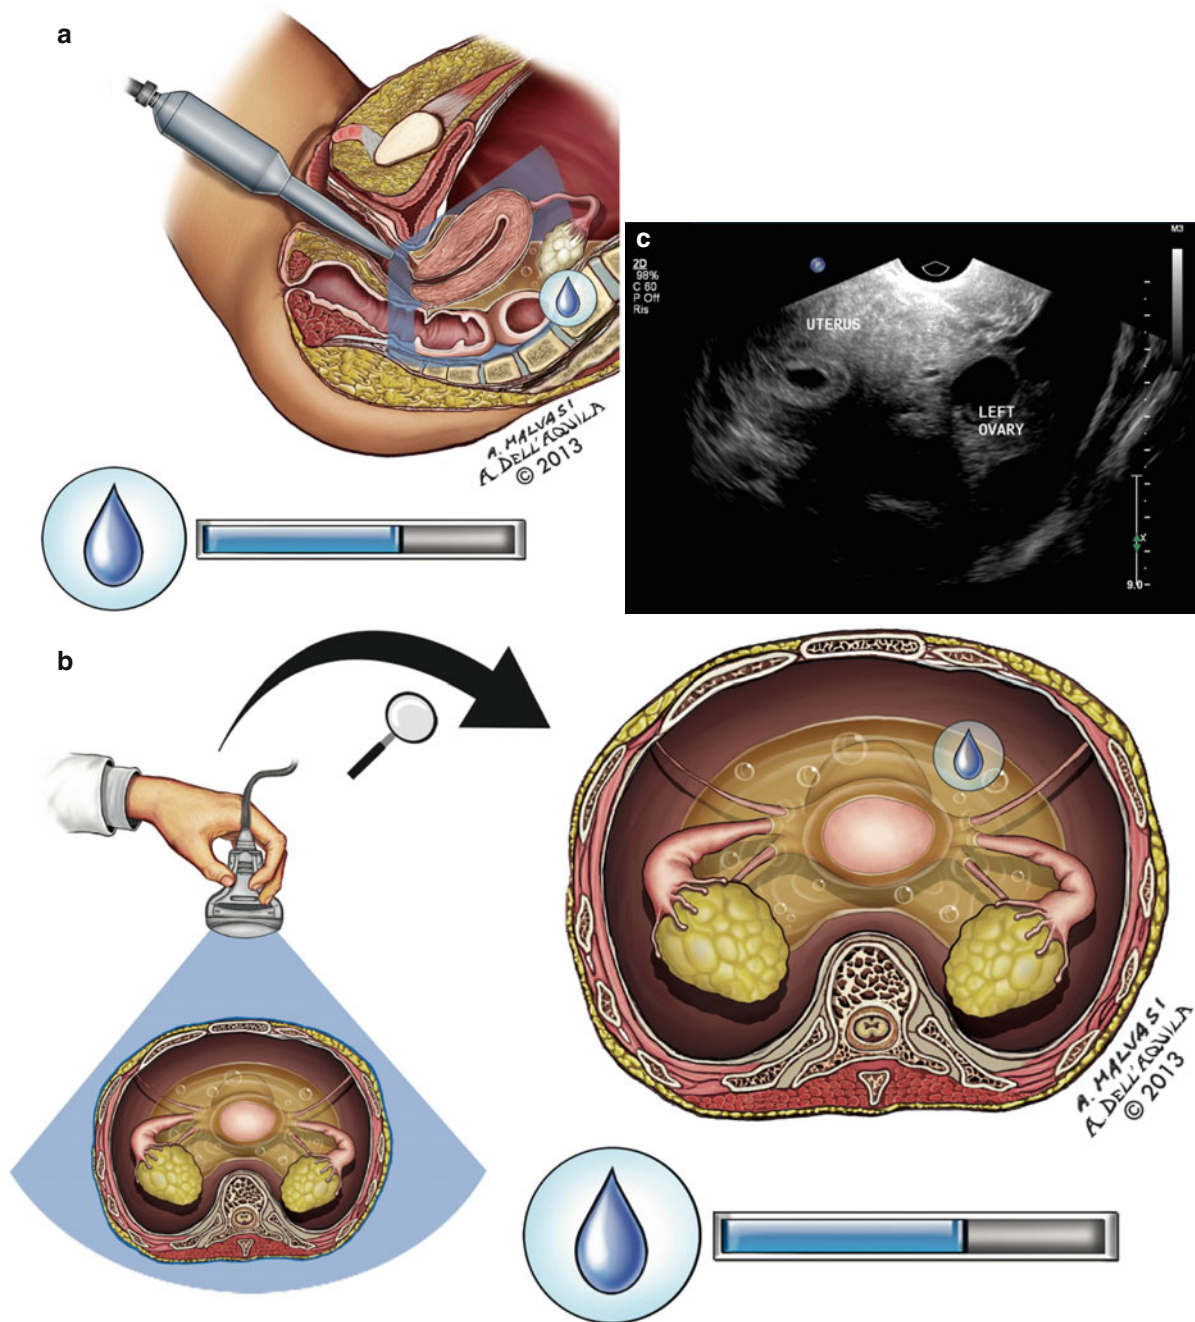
(a, b) The moderate ovarian hyperstimulation syndrome (OHSS) is represented, on the left, by a transvaginal ultrasonographic (US) scan and, in the middle, a transabdominal (US) examination, on the right an ultrasonographic photo
